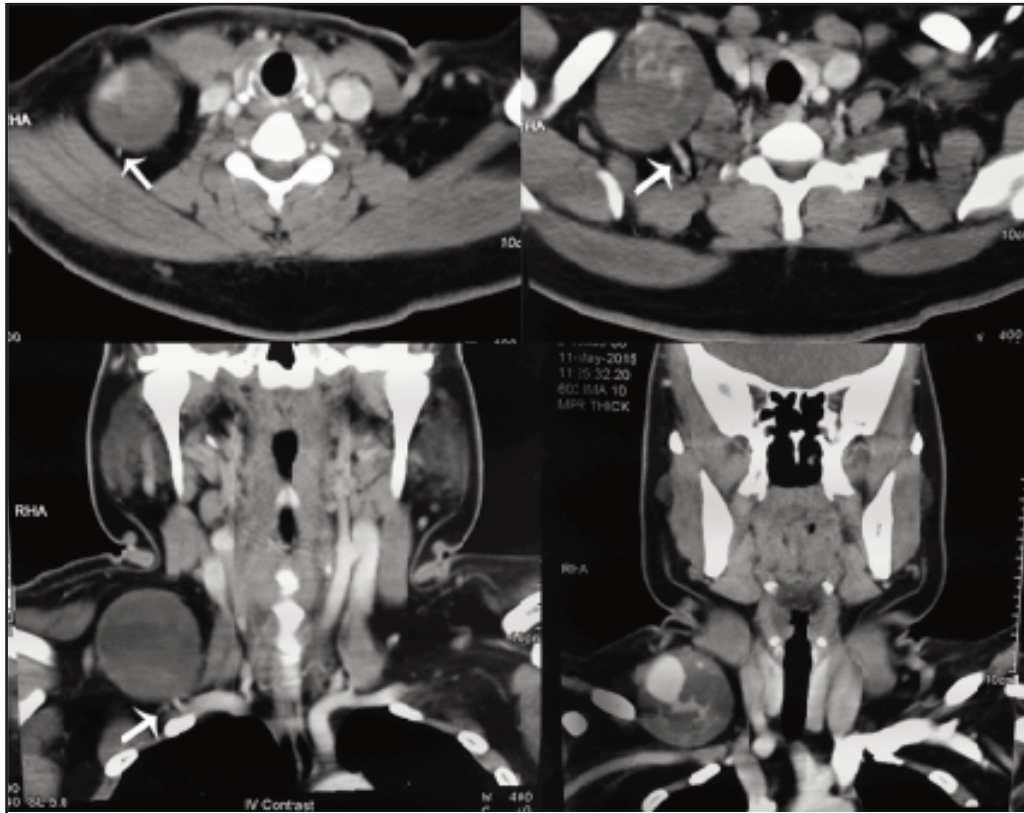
CT films showing a distinct soft tissue mass with heterogeneous enhancement during the arterial phase, and clear washout on delayed phase. There appears to be a feeding vessel (white arrow) into the mass originating postero-inferiorly.
